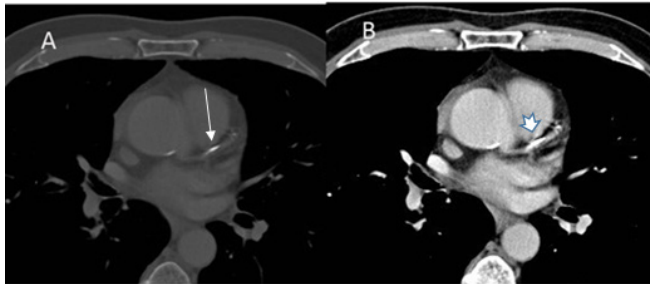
A 61-year-old hospitalised male with a history of HIV infection and cough underwent a diagnostic CT chest with contrast. (A) 3 mm axial image on bone window settings (width 2000 HU; level, 500 HU) shows a moderate calcified plaque in proximal LAD. (B) Corresponding soft tissue window image clearly shows presence of atherosclerotic calcification in LAD but with more blooming artefact.
